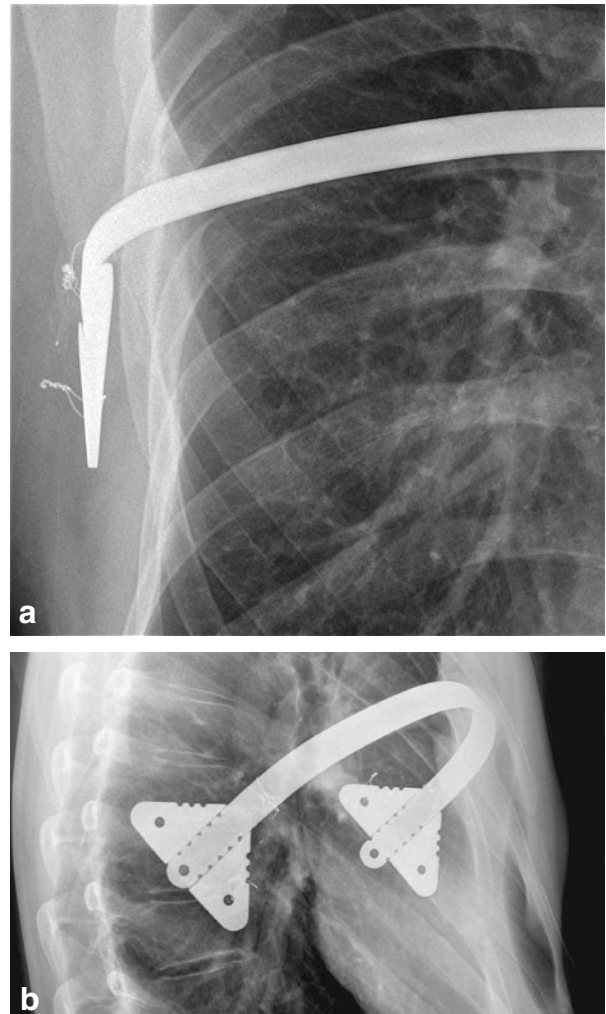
Right wing of a pectus-bar with attached triangular stabilizer, in a frontal X-ray aspect. Notice the broken fixation wires, potentially caused by dislocation of the pectus-bar wing and its stabilizer from the ribs. b Same situation in a lateral X-ray aspect. The twisting of the pectus-bar to cranially is clearly visible now, making the disruption of the wires understandable
